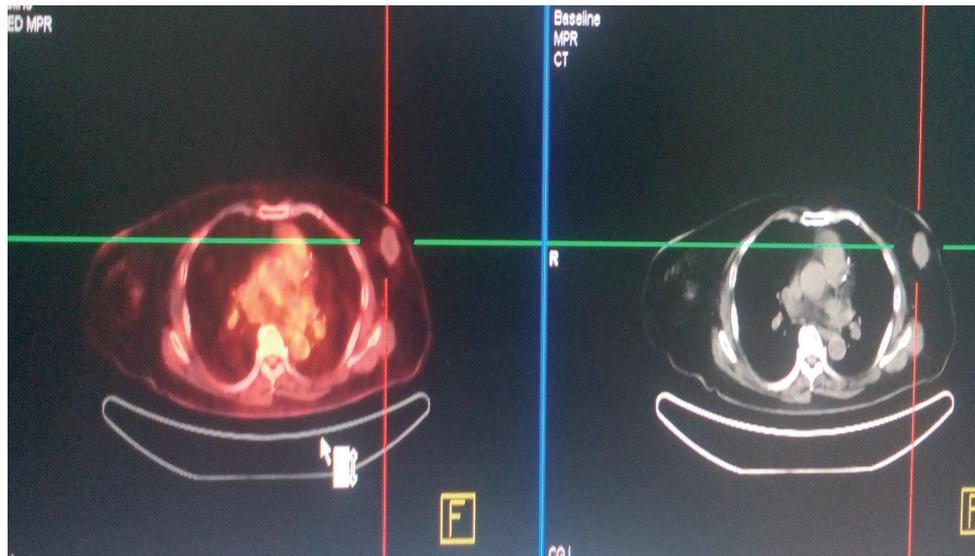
Axial PET-CT and CT images of patient categorized as a true negative.
